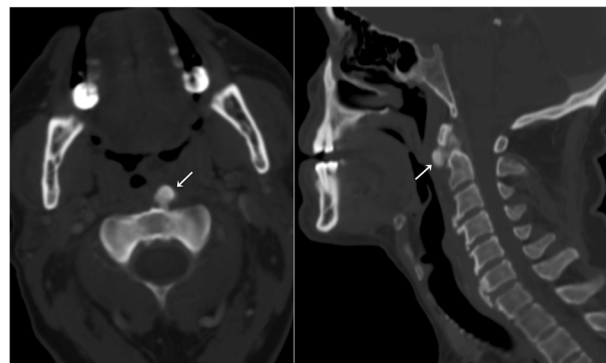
Axial (left) and sagittal (right) CT images in bone window. An amorphous intermediate density nodular calcification is seen in the prevertebral muscles anterior to C2 (arrows). In this clinical context, this imaging appearance is typical of acute calcific tendinitis of the longus colli muscle.
